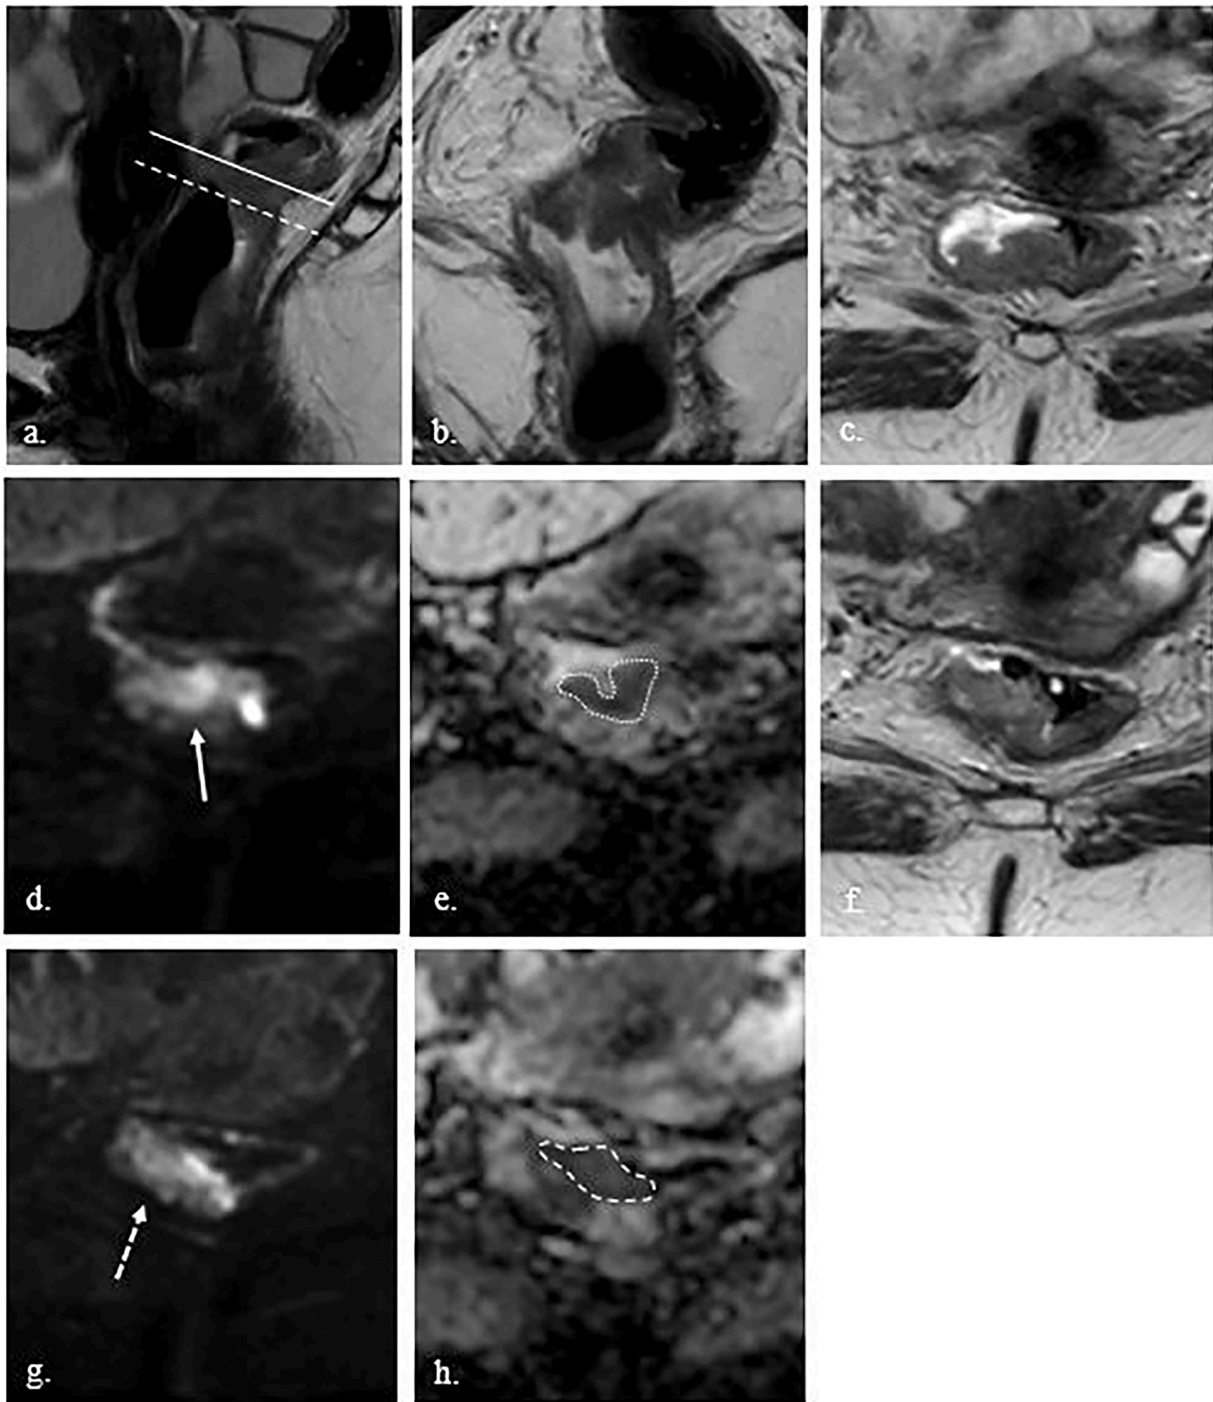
MRI performed for primary tumour staging in a 65 year old female.
